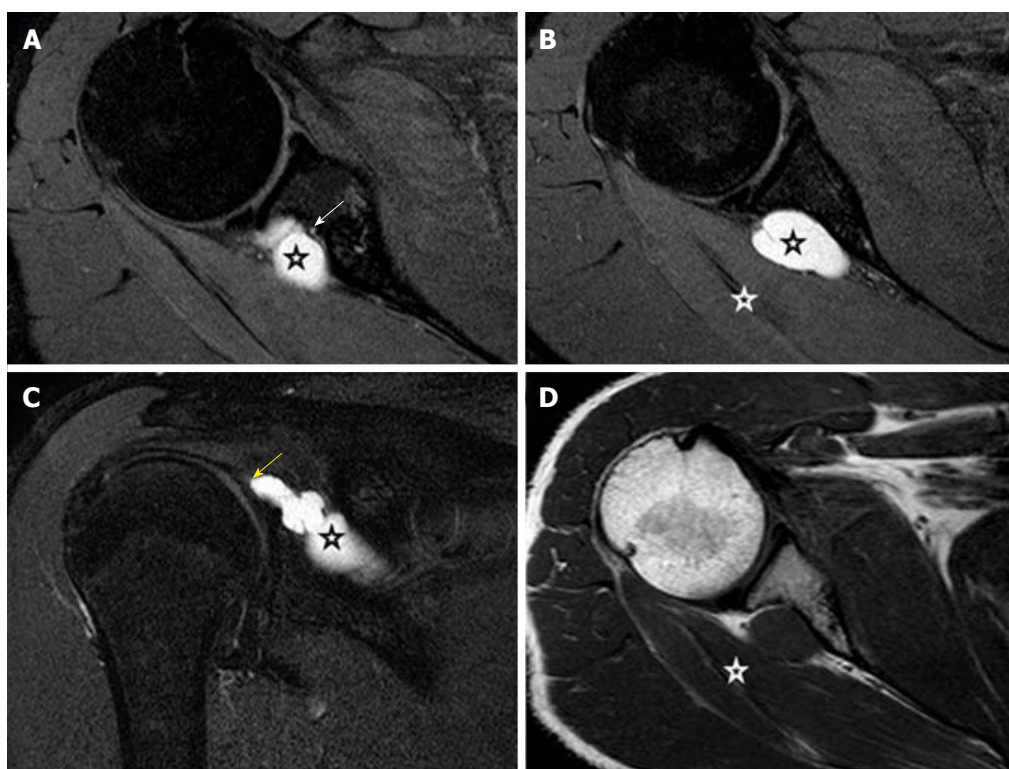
Proton density fat suppressed, serial axial (A, B), coronal (C) and T1-weighted, axial (D) show a well-defined lobulated slightly elongated cystic lesion (black stars) at the spinoglenoid notch compressing upon the suprascapular nerve (white arrow), which is seen separately from the cyst with preserved fat plane. There is a tail like communication (yellow arrow) of the cyst with the posterior labrum. This suggests labral tear with paralabral cyst formation. Denervation edema and mild volume loss in the infraspinatus muscle (white stars) is seen.
